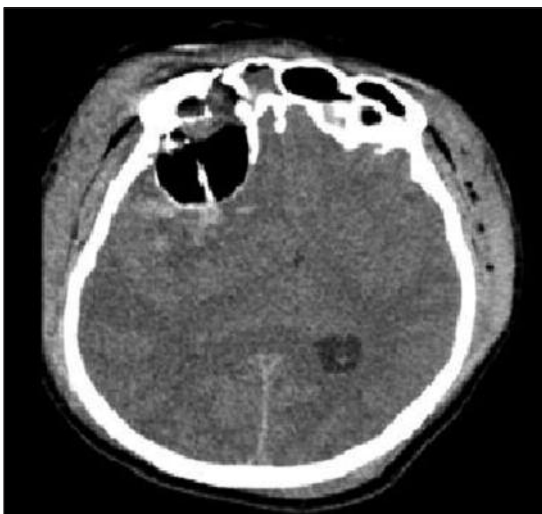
Axial computed tomography of the patient showing the foreign body penetrating the cranium and causing cerebral contusion, hemorrhage, and shift effect.
